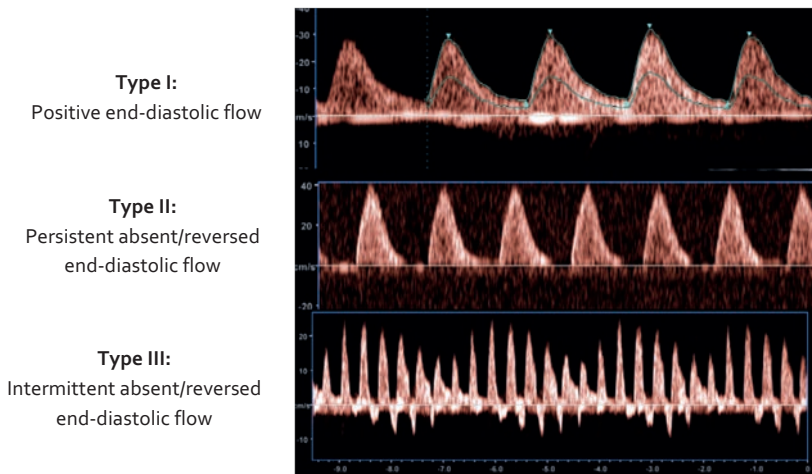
The Gratacós classification based on the Doppler flow pattern in the UA of the smaller twin.
